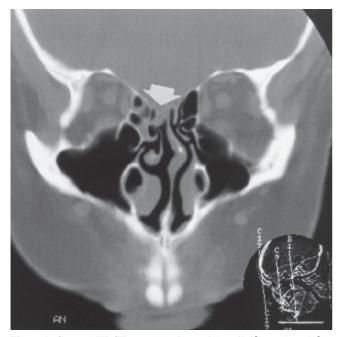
Coronal HRCT scan showing a right cribriform plate defect with a small encephalocoele.
